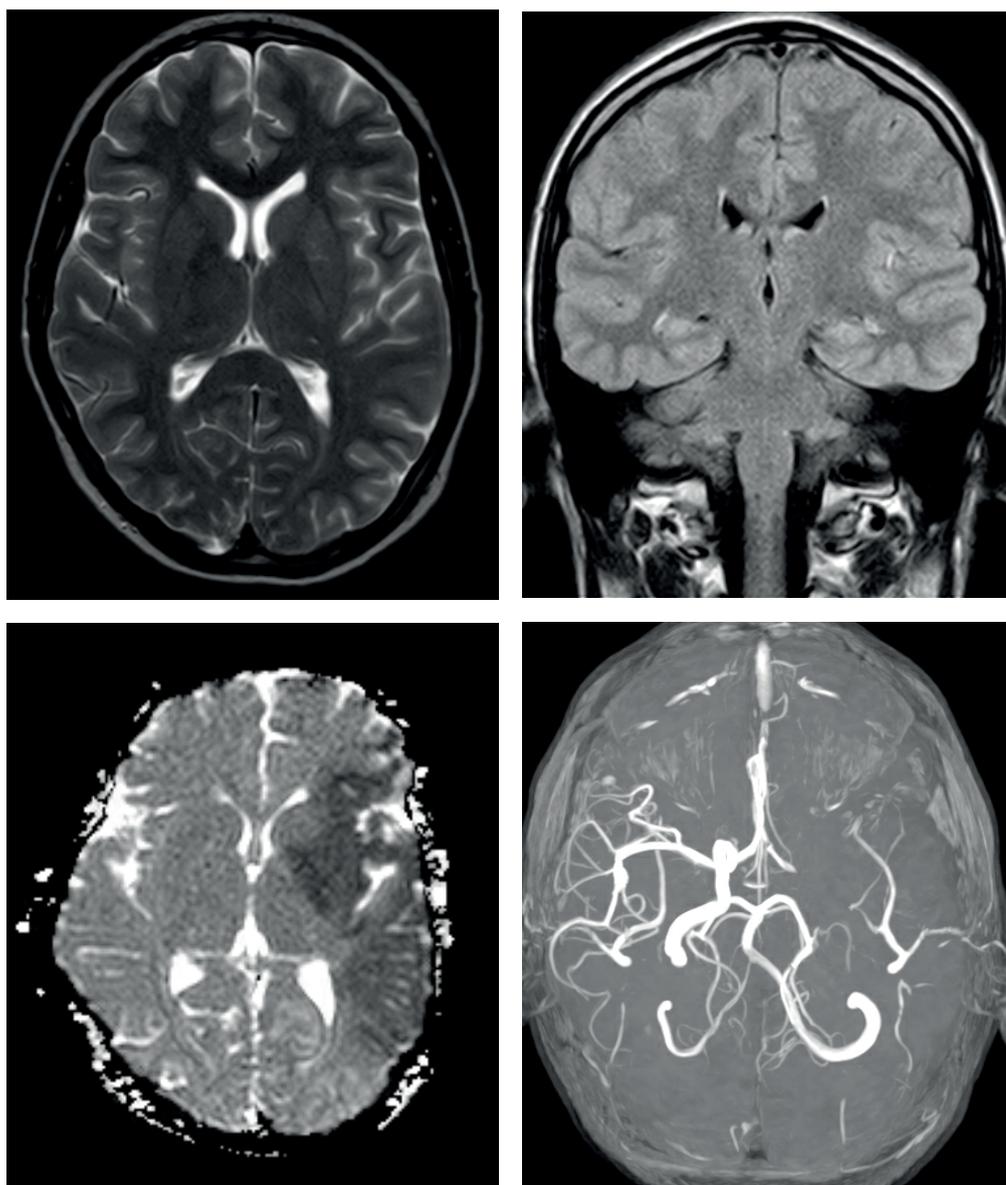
Initial Magnetic resonance imaging of the brain, occlusion of the left internal carotid artery and left middle cerebral artery, extensive area of restricted diffusion refers to acute ischemic changes.
